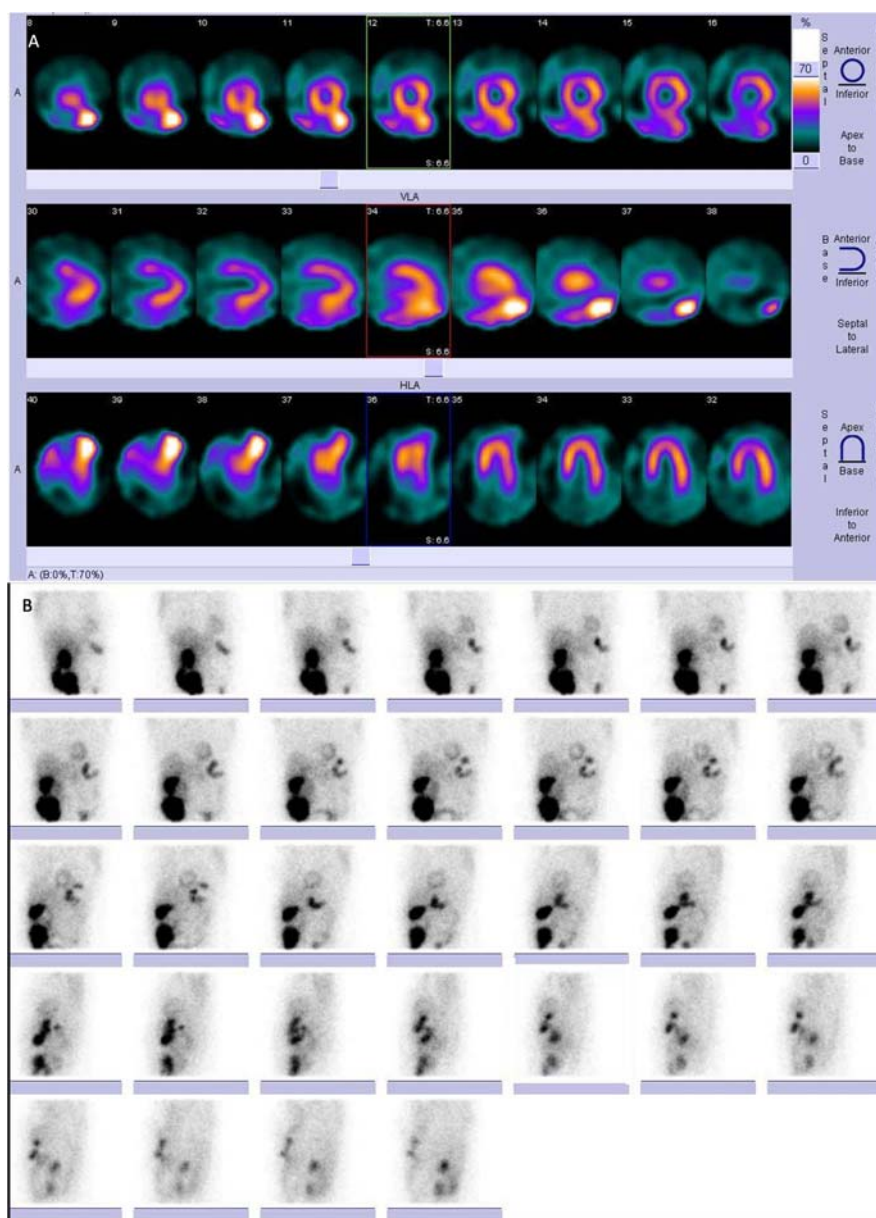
Processed images (A) and raw projections (B) of 1.5 hour SPECT of the patient.
